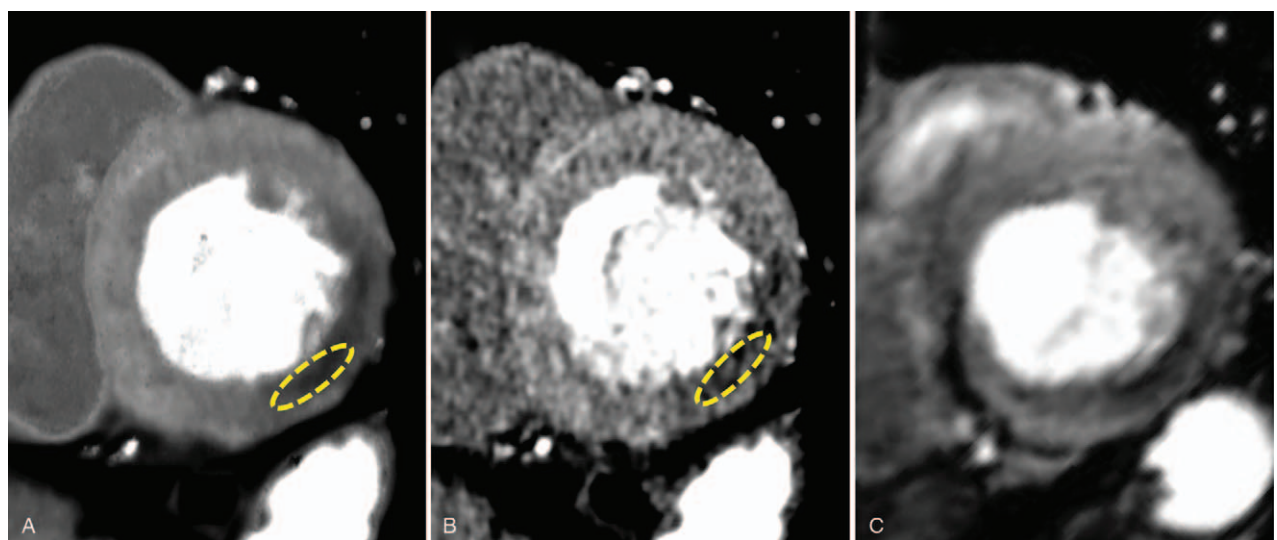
A case of a man in his 70s with severe stenosis in the left circumflex artery. The clarity of ischemia at the lateral wall in the basal level is higher with 4-dimensional similarity filter (4DSF) (A) than with adaptive iterative dose reduction 3D (AIDR3D) (B), because of less image noise; corresponding stress myocardial perfusion MR image (C) for reference. For example, the region of interest in the American Heart Association segment 5 is placed as shown in (A, B) for the calculation of contrast-to-noise ratio. In this case, visual image quality scores (artefacts, contour sharpness, myocardial homogeneity) of 4DSF were (3, 3, 3) (A) and the scores of AIDR3D were (2, 3, 2) (B).
